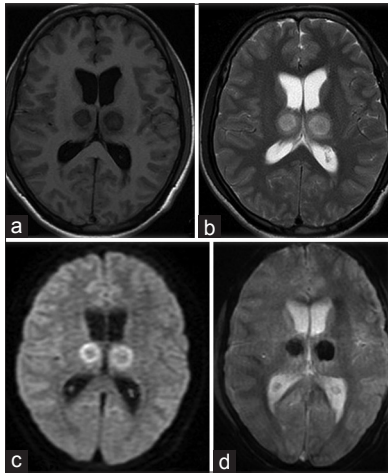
Axial magnetic resonance imaging showing well-defined T2 hyperintense (a) and T1 hypointense areas (b) involving thalami, lesions are showing restriction on diffusion weighted images (c) and blooming on gradient echo sequence (d)
